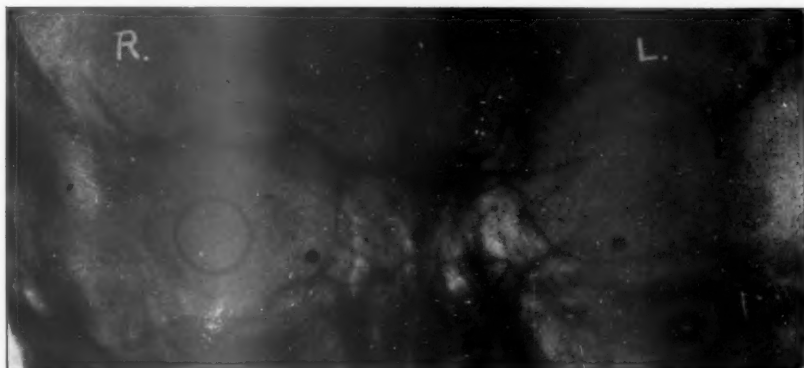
Antero-posterior view of X-ray picture with Wessely prosthesis.
